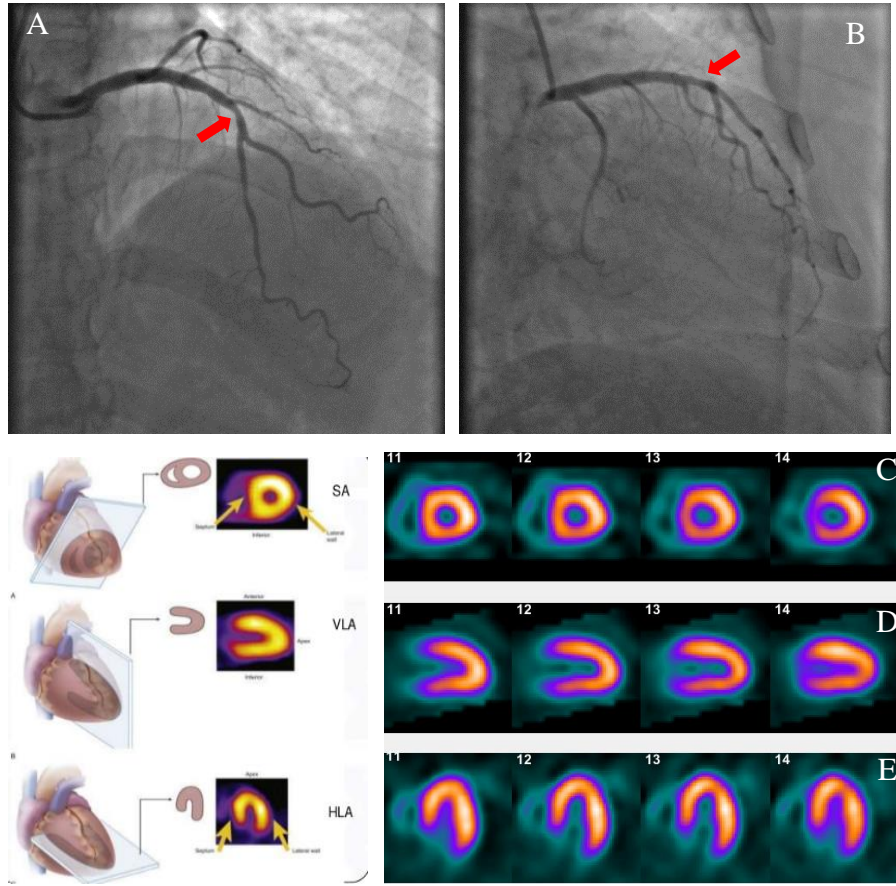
Fluoroscopy angiograms and single-photon emission computed tomography (SPECT) images.*
